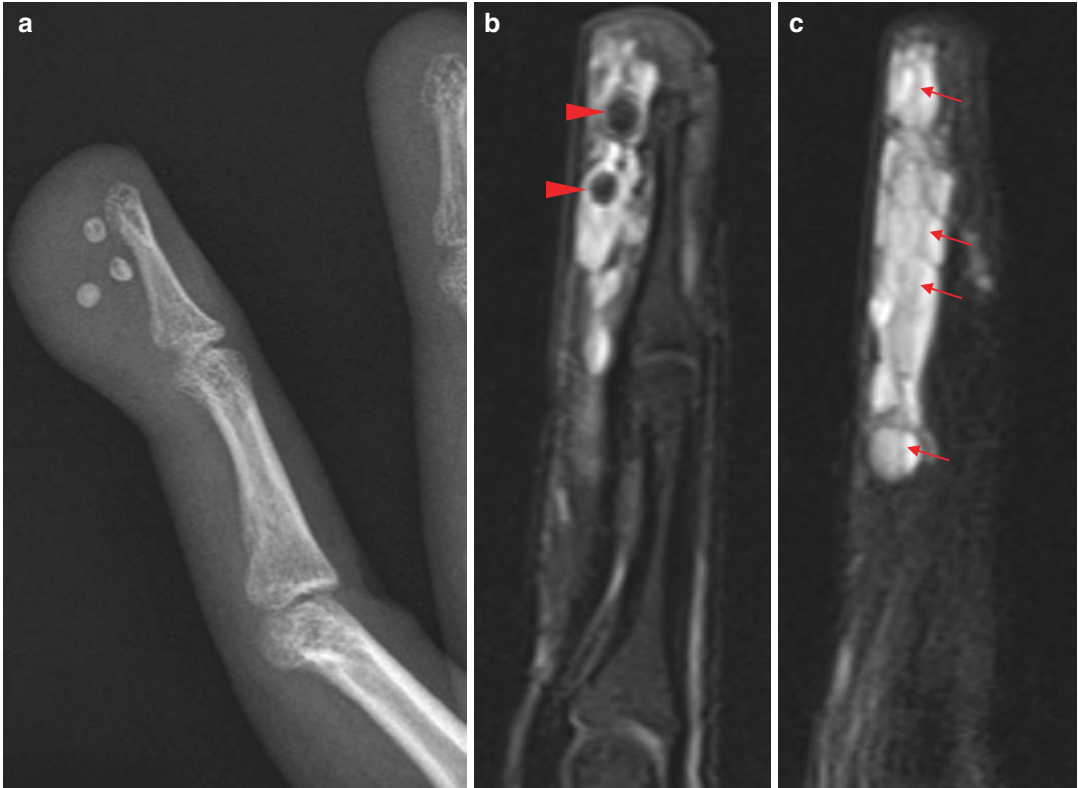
Hemangioma. Radiograph of finger (a) shows several calcifications with the classic appearance of phleboliths and dystrophic mineralization in an organizing thrombus. Sagittal FS T2WIs (b, c) show round or
